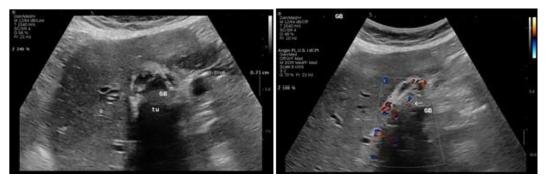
Conventional and Doppler US showing infiltration of gallbladder walls.
